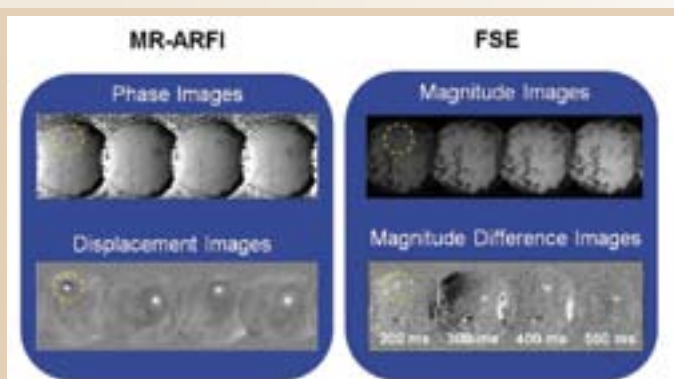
Example images for 4 out of 6 locations. Top-left: phase images obtained with encoding gradients in the opposite direction of the ultrasound beam; bottom-left: MR-ARFI displacement maps; top-right: FSE magnitude images obtained during sonications. Bottom - right: FSE difference images.
